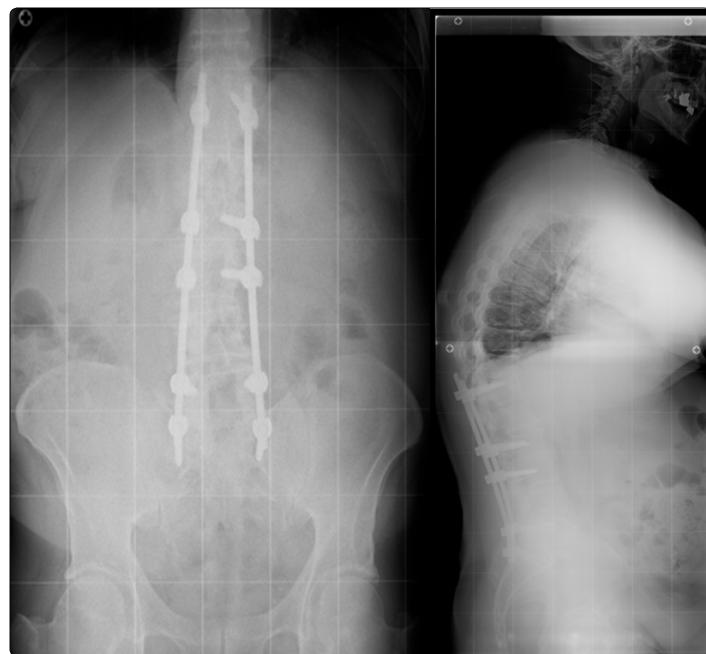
X-ray of the vertebral column, both antero-posterior and latero-lateral projections. They show the position of the stabilisation bars.
